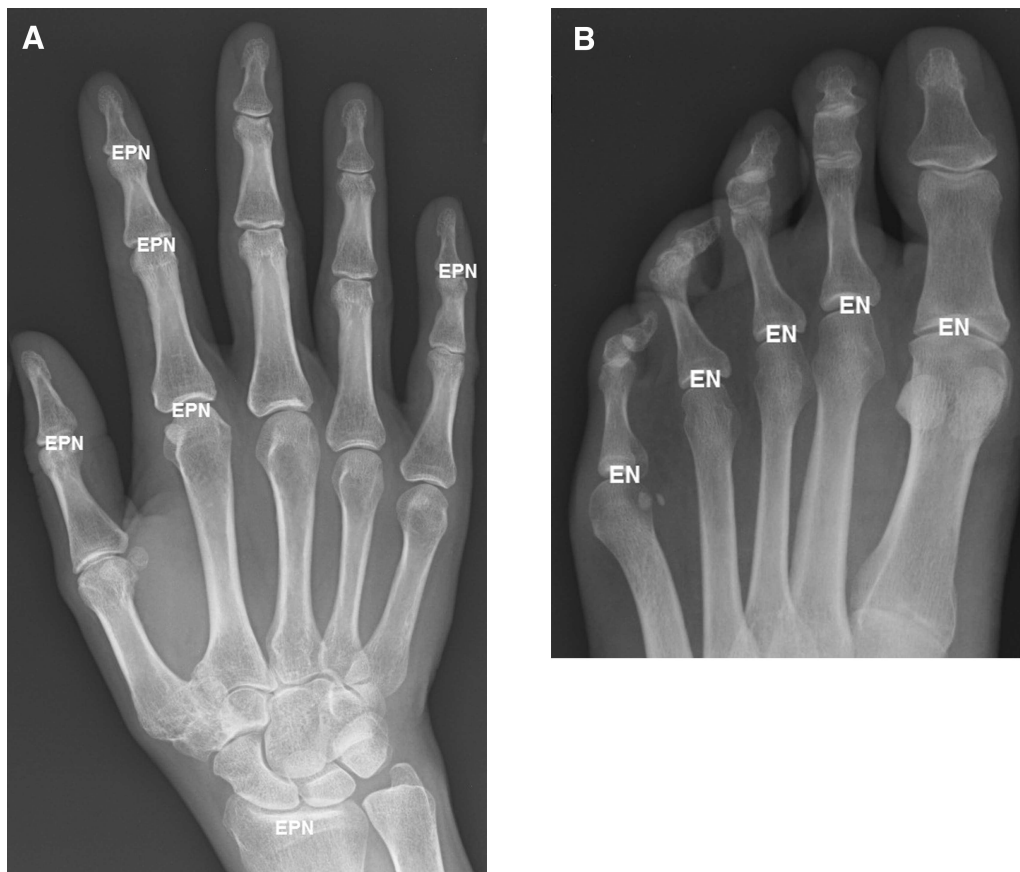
Joints assessed in the ReXSPA score. ReXSPA: The Reductive X-ray Score for Psoriatic Arthritis; E: erosion; P: osteoproliferation; N: joint space narrowing.
